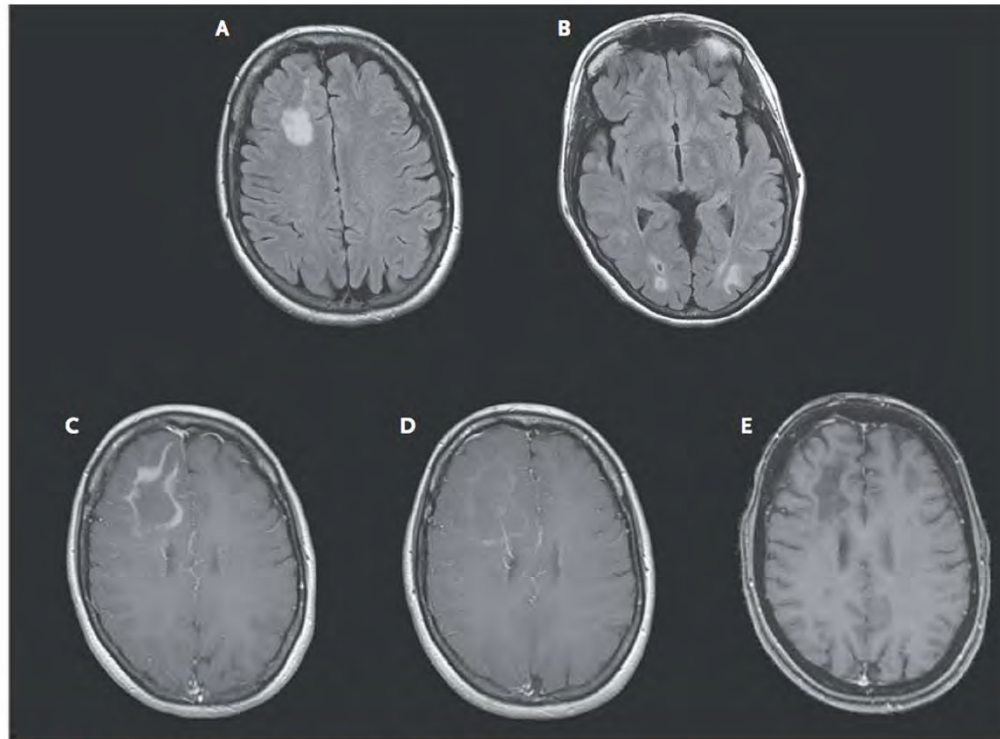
Sequential Magnetic Resonance Images of the Brain.
